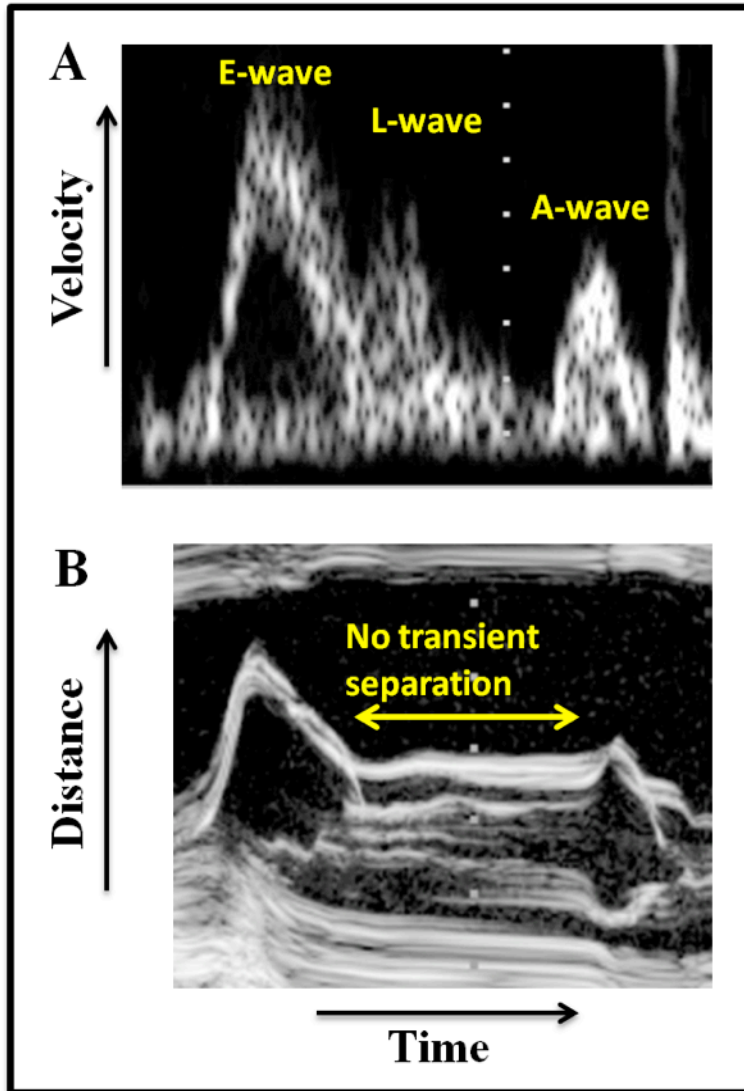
(A) Two-dimensional Doppler transmitral velocity profile showing the early filling (E-), L-wave and the atrial filling (A-) wave. (B) Parasternal M-mode image in the same subject showing mitral leaflet tip motion. Mitral leaflets remain coapted, with no transient leaflet separation during diastasis indicating absence of transmitral flow during the L-wave. See text for details.
